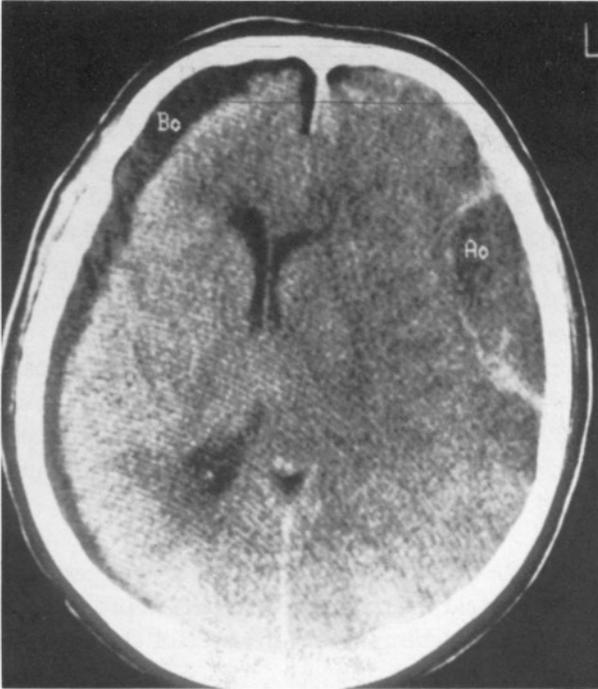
CT revealed ventricular compression bilaterally, and shift of the midline structures to the right.
